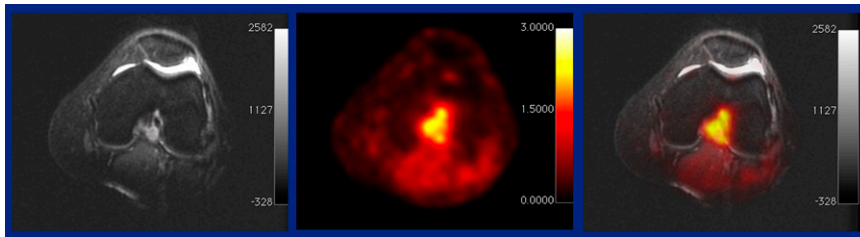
Sigma-1 receptor (S1R) ^{18}F -FTC-146 PET/MR imaging in patients with knee pain. Example of S1R PET abnormality in the intercondylar notch of the knee (middle), where no corresponding abnormality was visualized on MR imaging (left). S1R PET/MR (right) guided arthroscopic surgical resection of the synovial mass resulting in complete resolution of pain.
